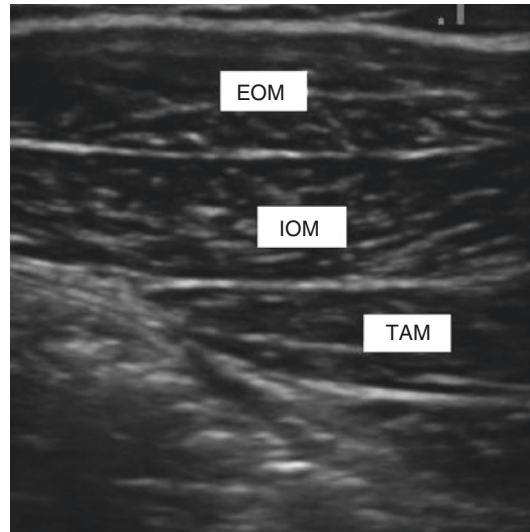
Ultrasound image showing the layers of abdominal muscles. *EOM* external oblique muscle, *IOM* internal oblique muscle, *TAM* transverse abdominal muscle [5]
